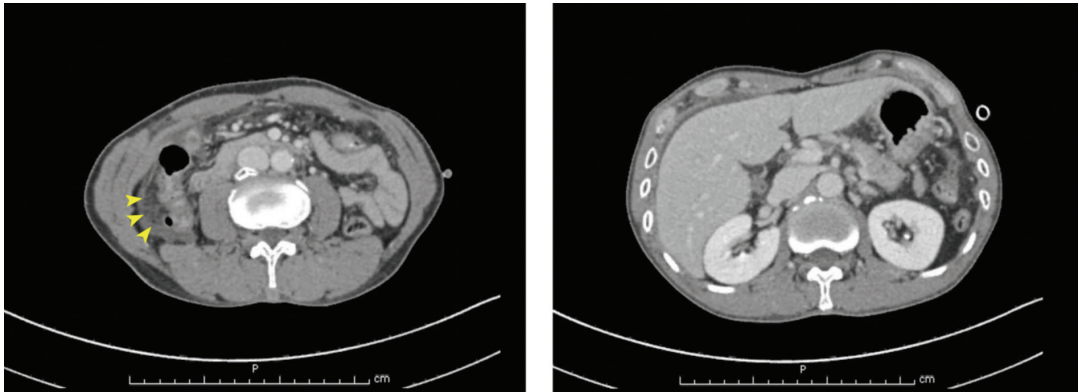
Computed tomography (CT) scan of the abdomen shows diffuse fat reticulation (arrowheads) in right paracolic gutter region and multiple diverticula involving ascending colon without signs of diverticulitis
